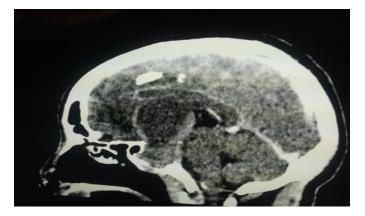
Contrast enhanced CT of the brain showing mildly enhancing large pituitary mass extending to the optic chiasma.
